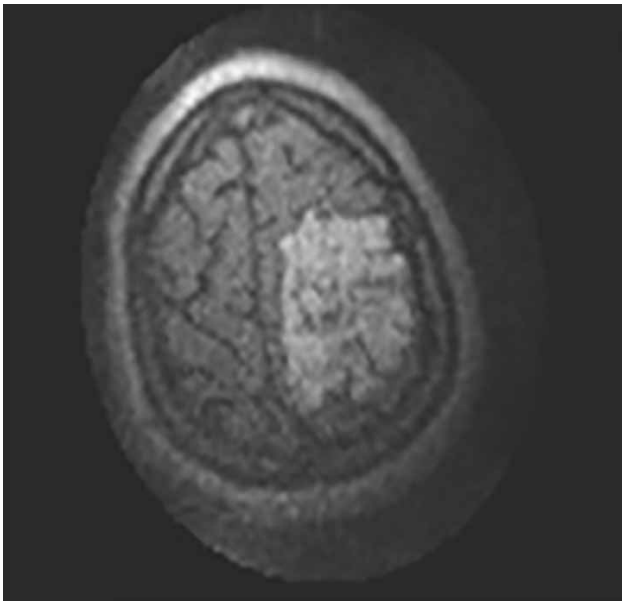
Hyperintense lesion was seen on the intraoperative MRI T1W axial plane.
